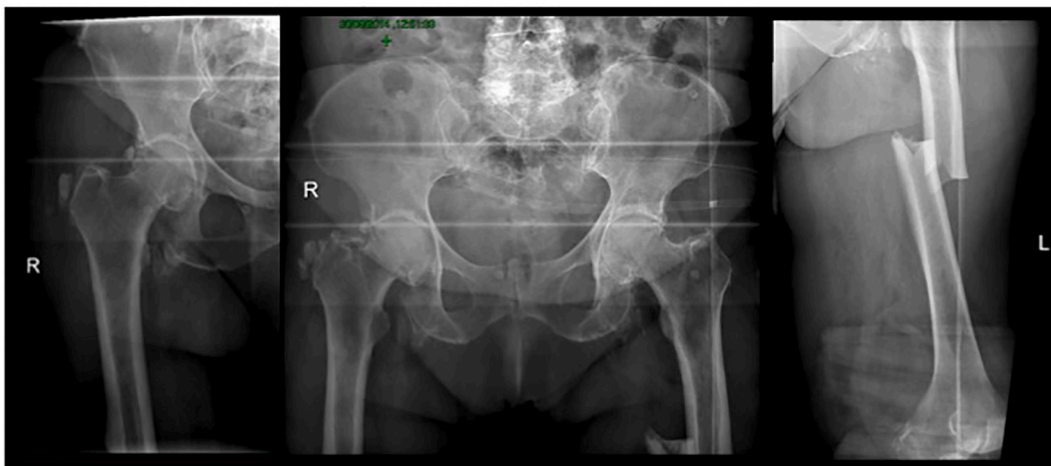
Radiographs demonstrating atypical femur shaft fracture on left limb and atypical pattern on right femur. Right: right femur antero-posterior x-rays. Centre: antero-posterior pelvis. Left: left femur antero-posterior x-rays. (September 2014).
